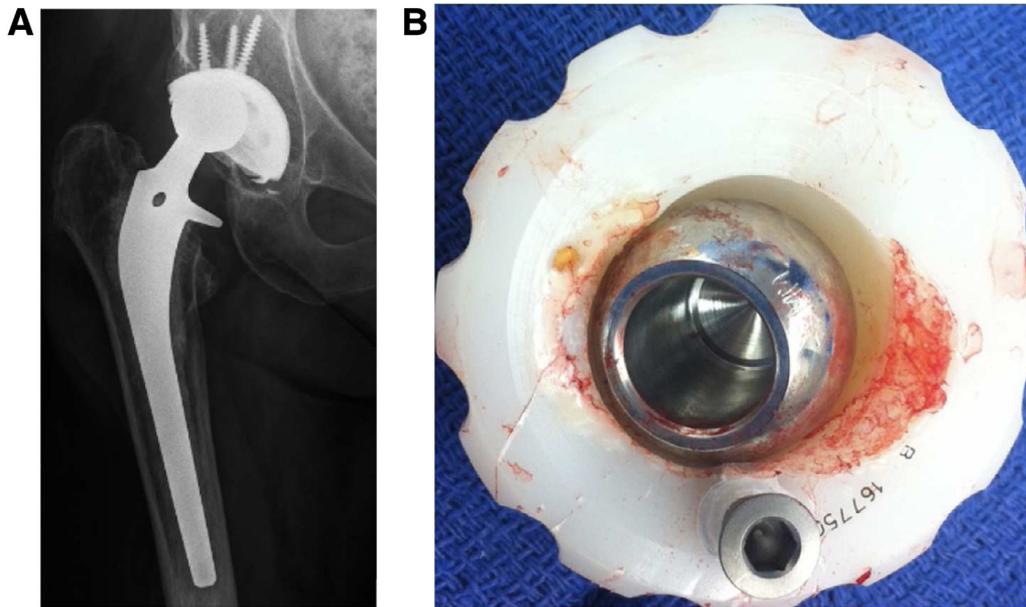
Demonstrates PE wear resulting in late instability of THA. (A) Radiograph of the affected hip. Note the eccentric position of the femoral head relative to the acetabular component. (B) Gross image displaying PE wear. The screw located in the inferior aspect of the liner was used to assist with removal.
